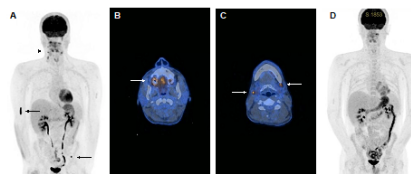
(A) PET-CT before teclistamab with PBL manifestations in the cervical lymph nodes and osseous lesions of the humerus, maxilla and iliac bone (arrows). Axial images of the primary lesions in the maxillary bone (B) and cervical lymph nodes (C, arrows). (D) PET-CT after treatment with almost complete normalization of the FDG-signal of all previously described lesions.
